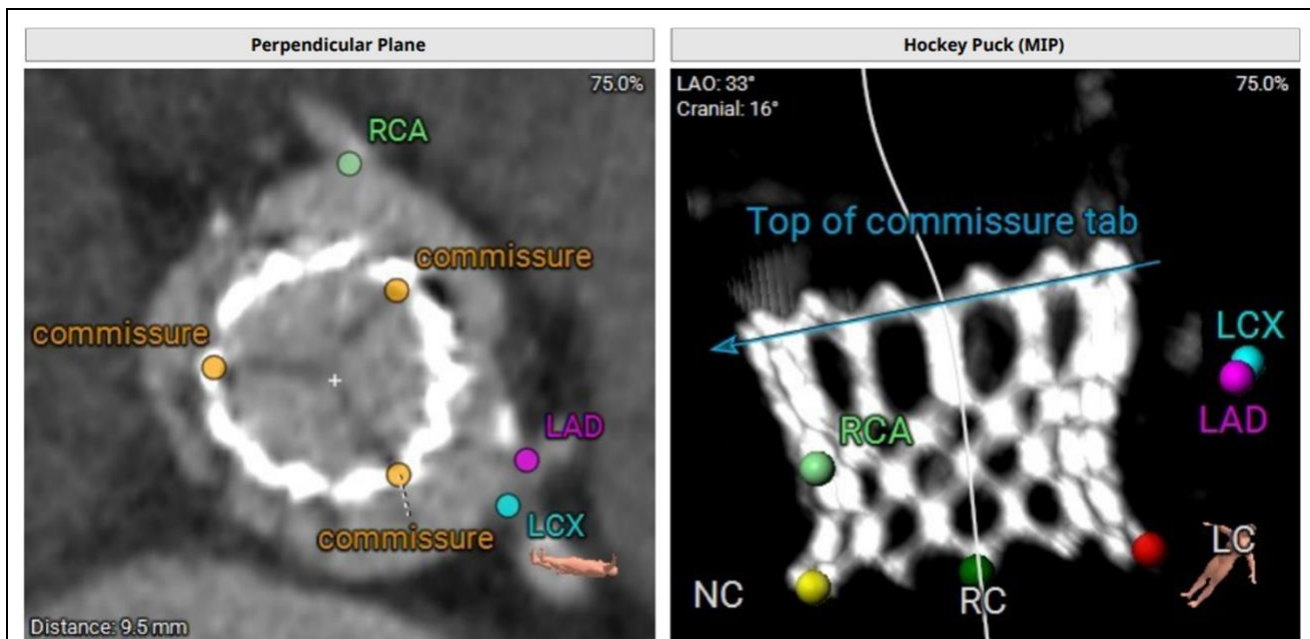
CT-based coronary obstruction risk assessment.
